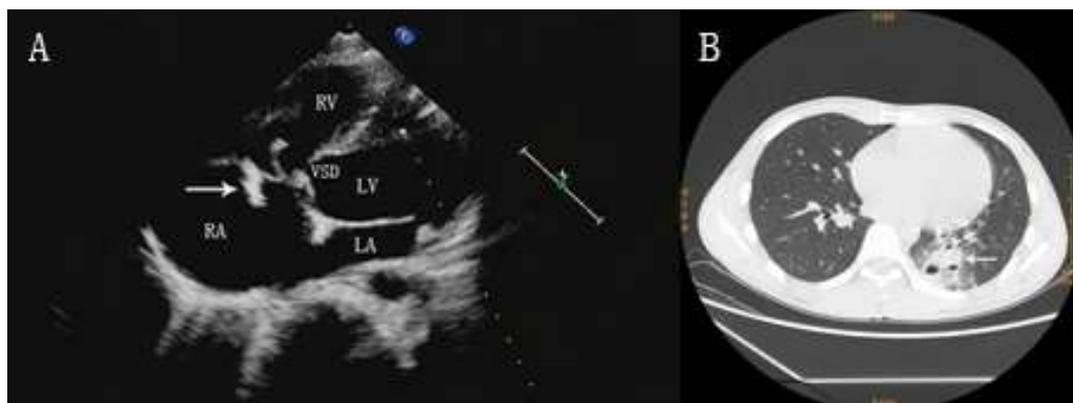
(A): The 4-chamber scan of echocardiography revealed membranous ventricular septal defect of 6mm and a 18×6mm vegetation was revealed on the anterior lobe of tricuspid valve. (B) The CT image showing flaky opacities with airbags in left lung.
